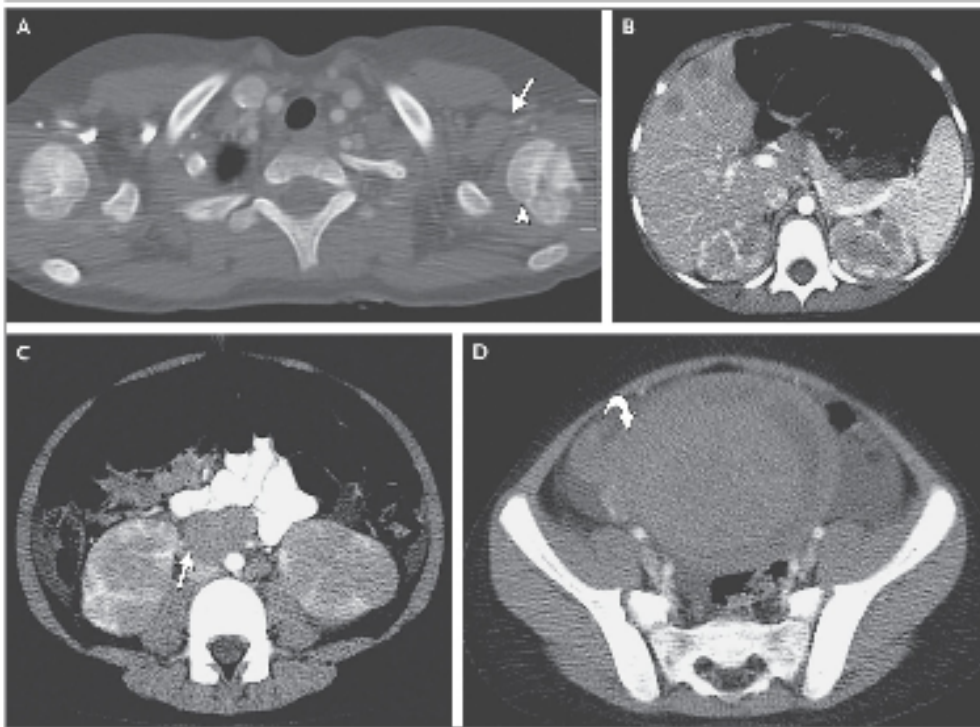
CT Images of the Chest and Abdomen with Intravenous Contrast Material.
